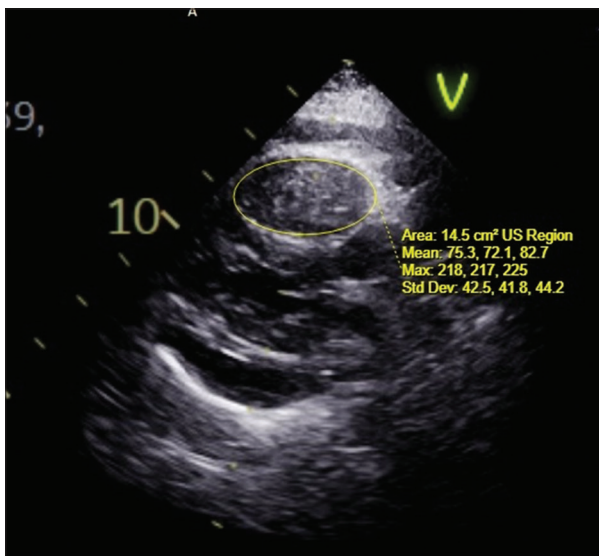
Transthoracic echocardiography showing a large mass involving the right ventricle and pericardium
